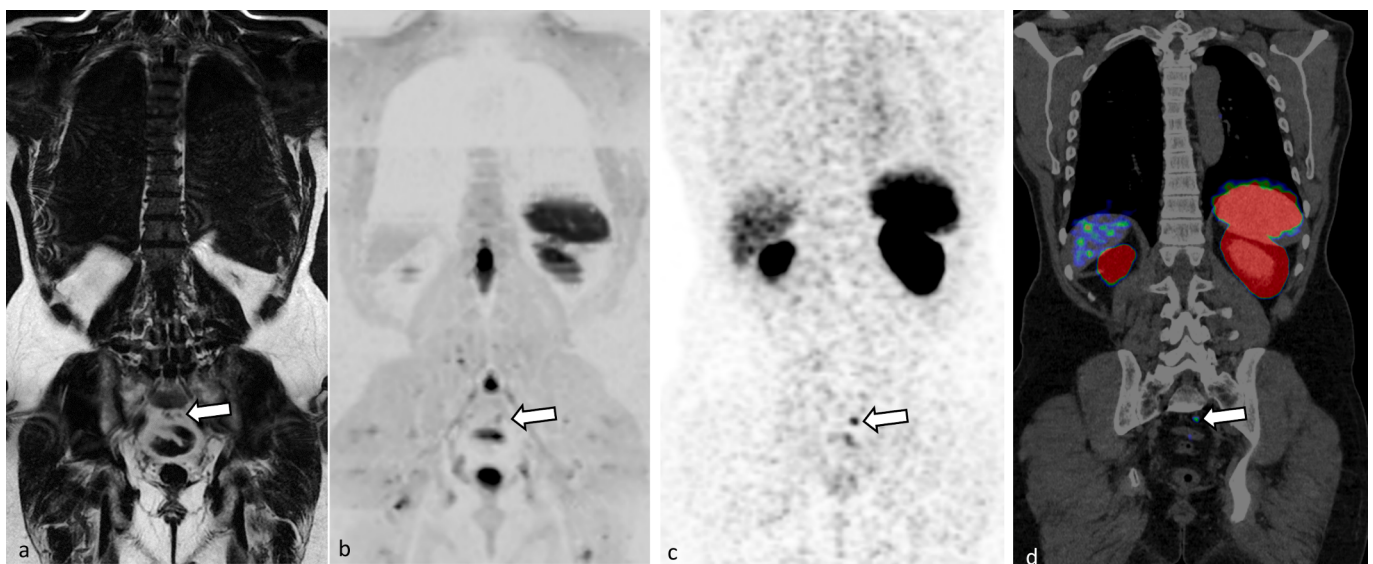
Discrepancy in lymph node staging between fast “All-in-One” WB-MRI and ^{68}Ga -PSMA-PET/CT, in a 58-year-old man with high-risk PCa. Panels a-b (fast “All-in-One” WB-MRI) show coronal WB-MRI T1 Dixon Fat only (a), and coronal reformatted DWIBS ($b = 1000 \text{ s/mm}^2$; inverted grey scale) images showed a retrospective left 4 mm presacral lymph node that was not considered metastatic due to its small size (arrow) (b). Panels c-d (^{68}Ga -PSMA-PET/CT) show coronal metabolic PET (c), and coronal reformatted fused PET/CT with a presacral lymph node metastasis with PSMA expression (arrow) (d).
